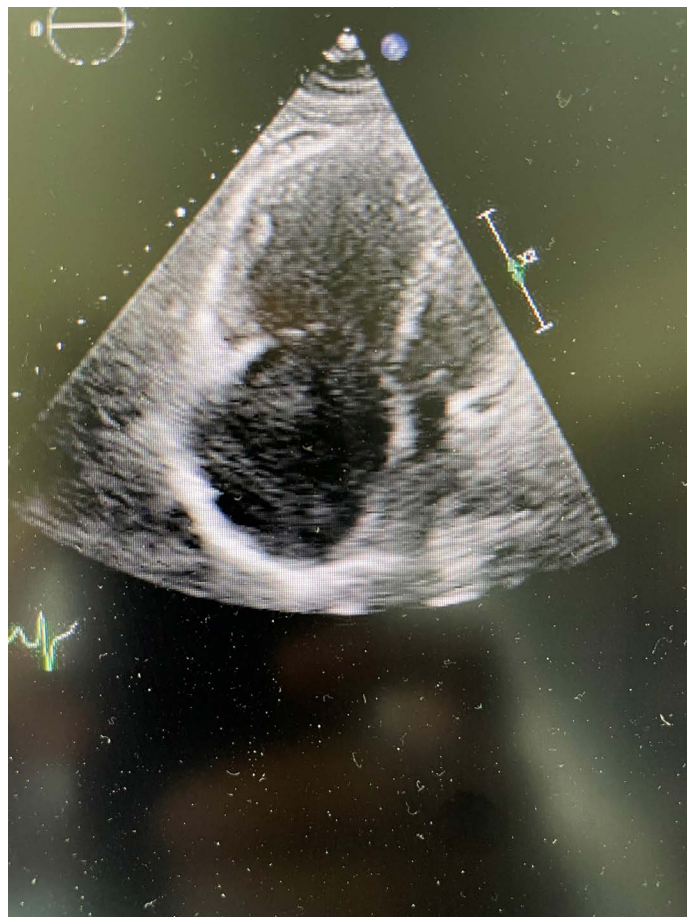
Partial anomalous pulmonary venous return (PAPVR) echocardiogram (ECHO).
